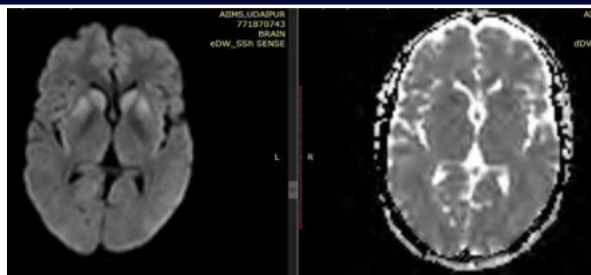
DWI SequenceFigure 5B:-ADC Sequence
